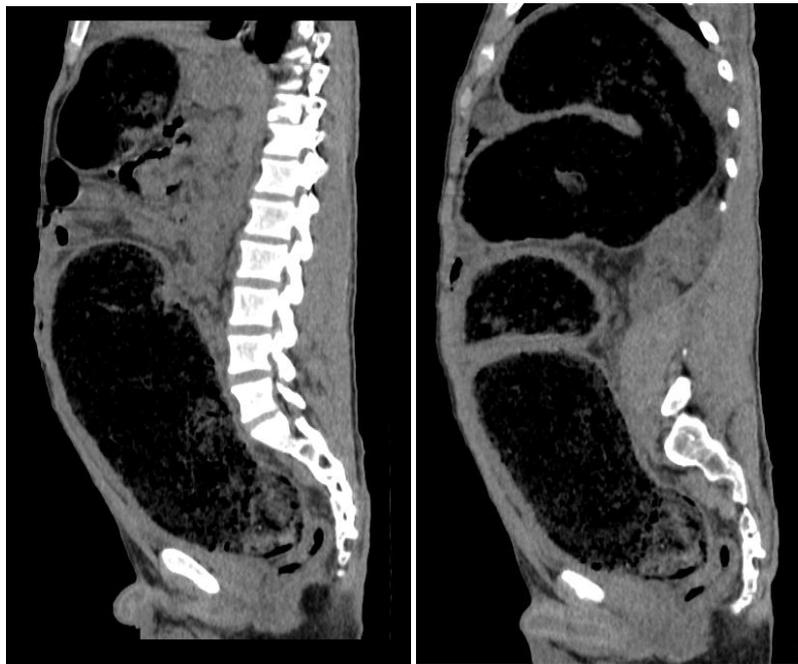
CT scan without injection, coronal section a dilatation of the colonic framework with absence of individualization of the colonic haustrations, without detectable zone of disparity of the caliber
